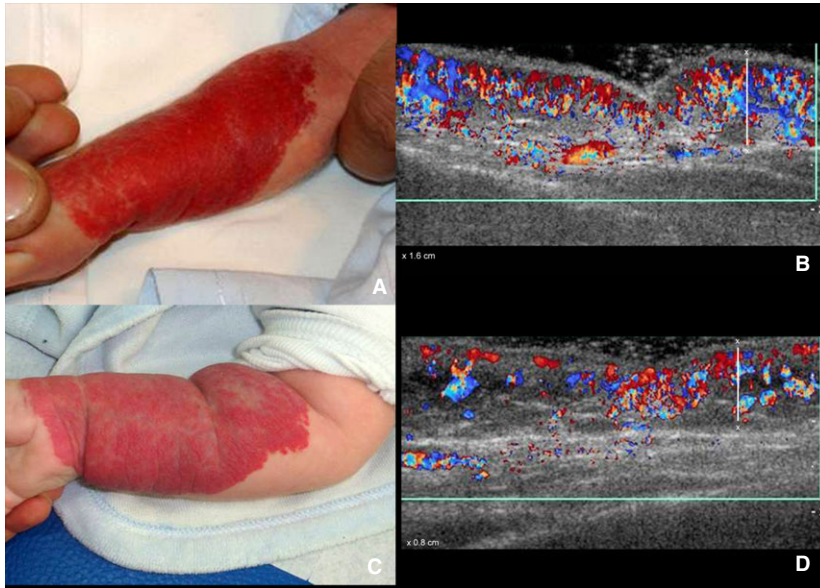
Hemangioma on the forearm. (A) Clinical evaluation before treatment. (B) Color Doppler ultrasound (CDU) evaluation before treatment shows diffuse hypervascularity within the lesion that affects the dermis and hypodermis. (C) Clinical follow-up at 3 months. (D) CDU follow-up at 3 months demonstrates isolated areas of hypervascularity within the same lesion. Thickness (x) measurements are shown in B and D (CDU longitudinal axes).
